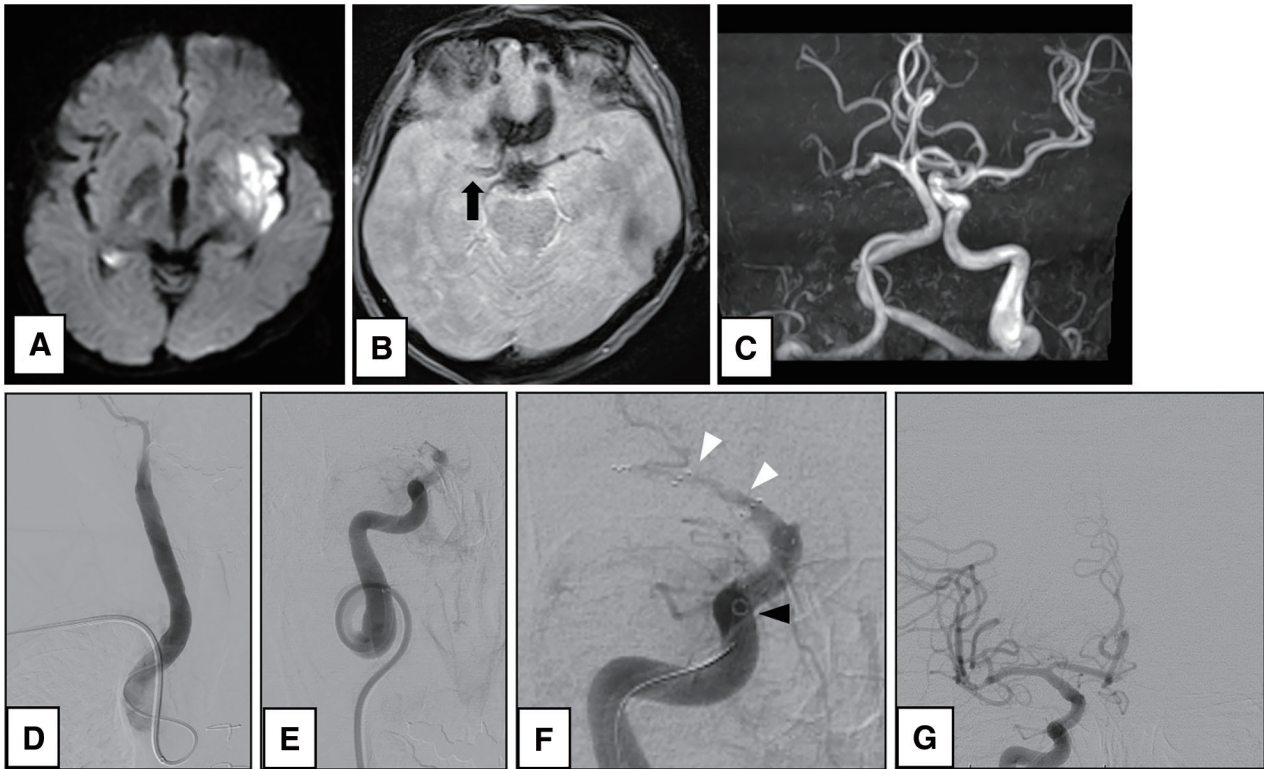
(A–C) On day 6, DWI showed a high-intensity area in the right insular cortex and deep white matter; T2-weighted imaging showed a low-intensity area (black arrow) in the right ICA; and MRA showed right ICA occlusion. (D) In the anterior view, the transbrachial approach was selected again, and cerebral angiography before MT showed right carotid artery occlusion. (E and F) In the anterior
